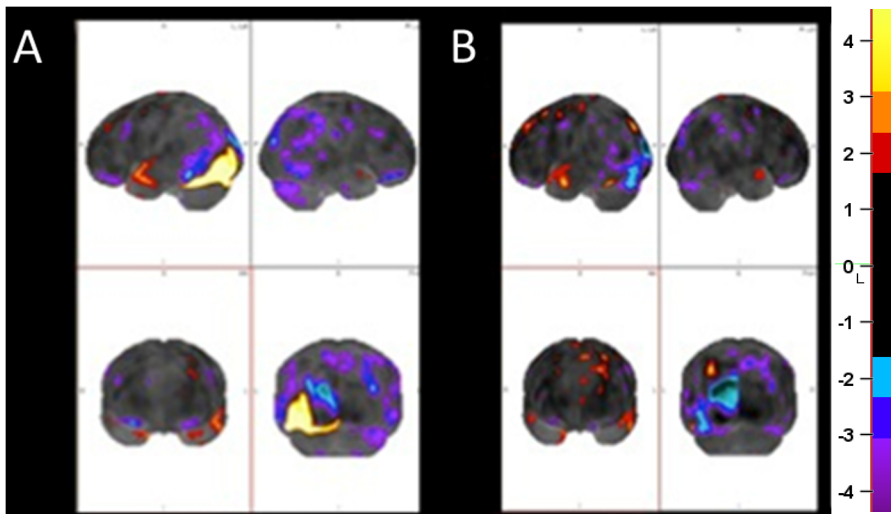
^{18}F -FDG PET Metabolic Z Score Cortical Surface Map Projections Compared to Healthy Controls
